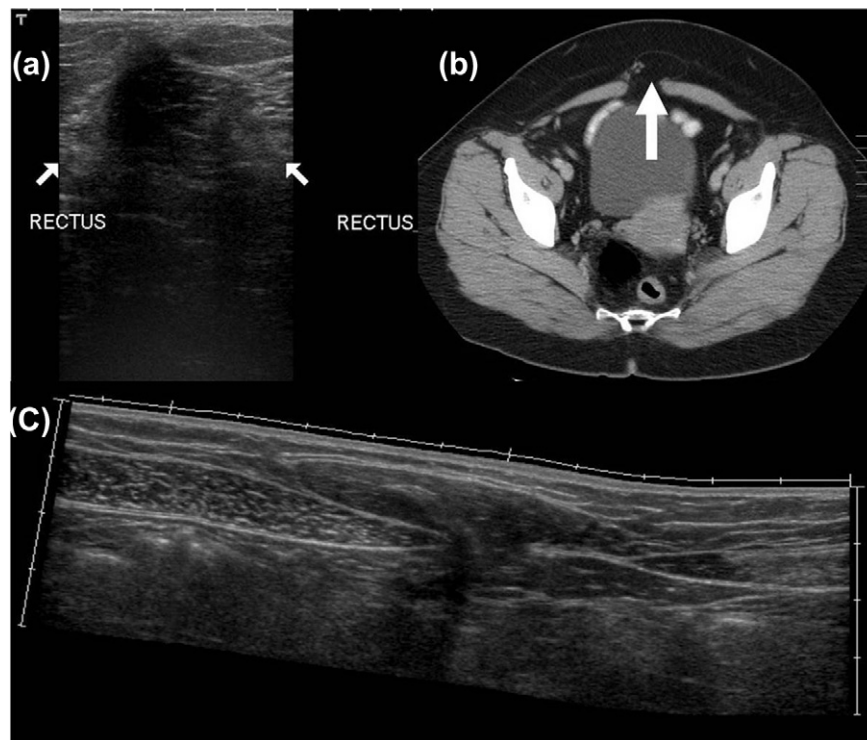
(a) High-frequency ultrasound showing a defect in the linea alba and abdominal fat herniating through the defect. (b) The findings are confirmed at CT. (c) The transverse panoramic view beautifully demonstrating the defect and abdominal contents herniating through it (compare this with the Fig 1).
